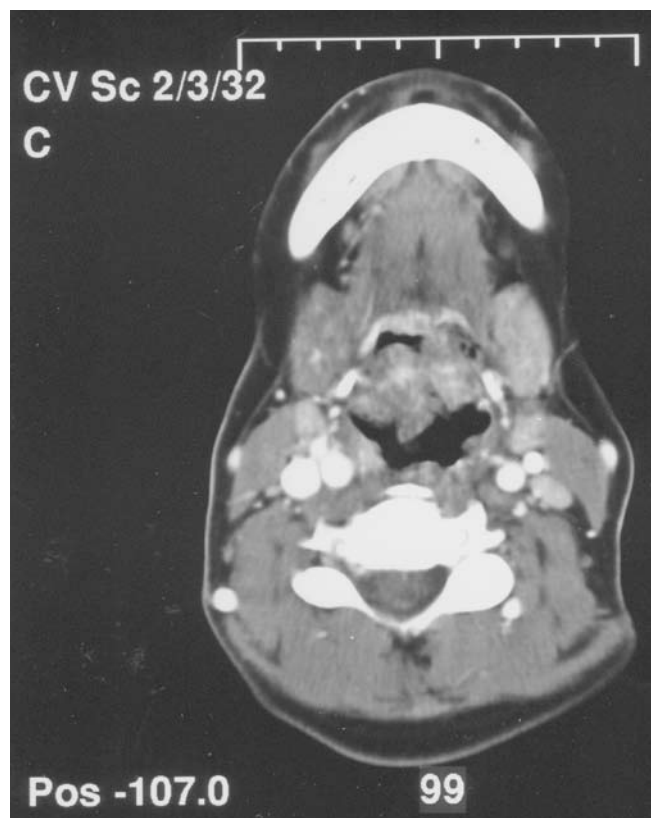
Axial CT scan of the neck showing the grossly enlarged and irregular epiglottis with bilateral cervical lymphadenopathy.
